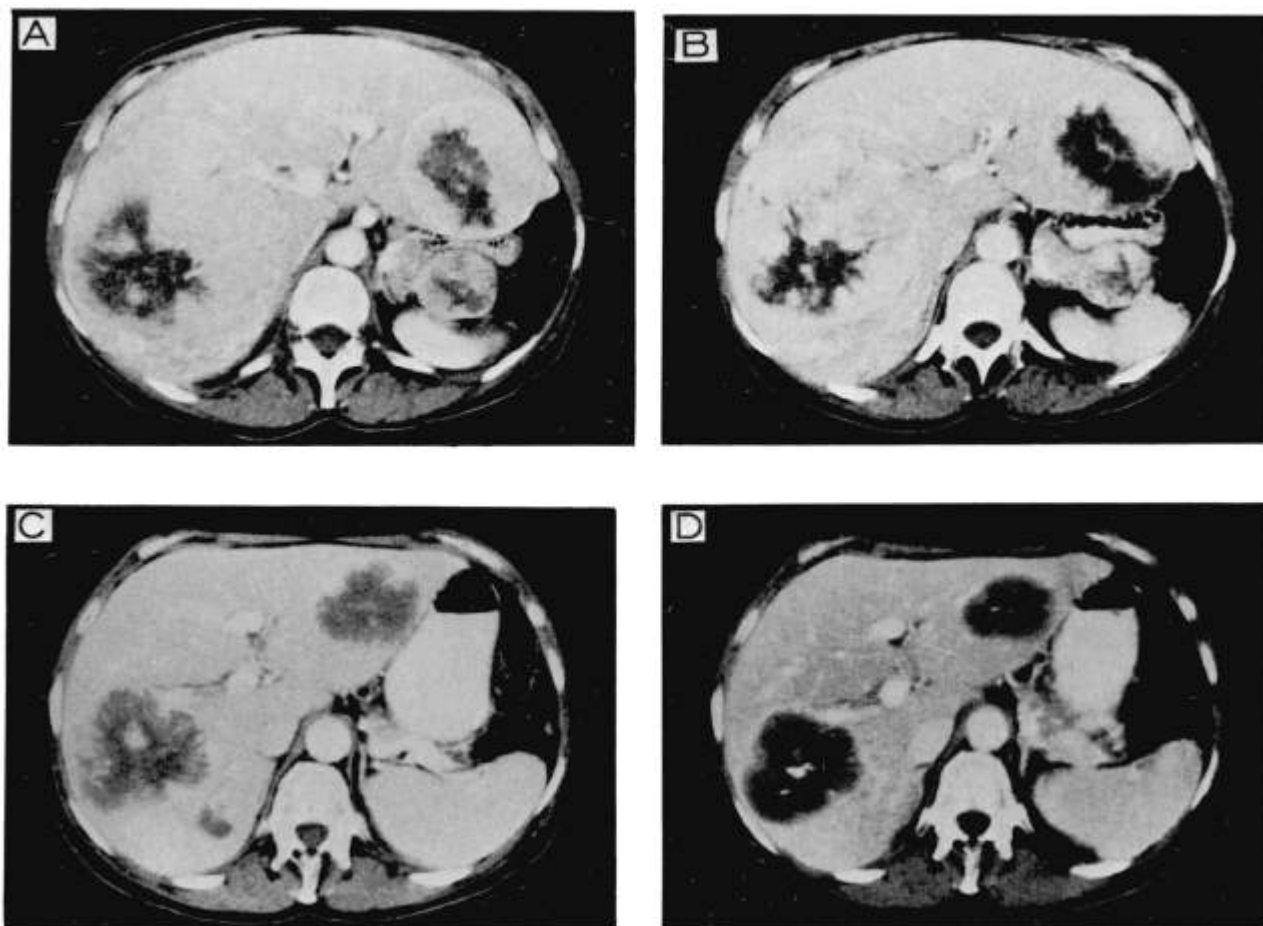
Consecutive contrast-enhanced CT scans of the liver prior to treatment (A), and after 6 (B), 12 (C) and 36 (D) months. This last scan shows early progression with renewed contrast enhancement.
